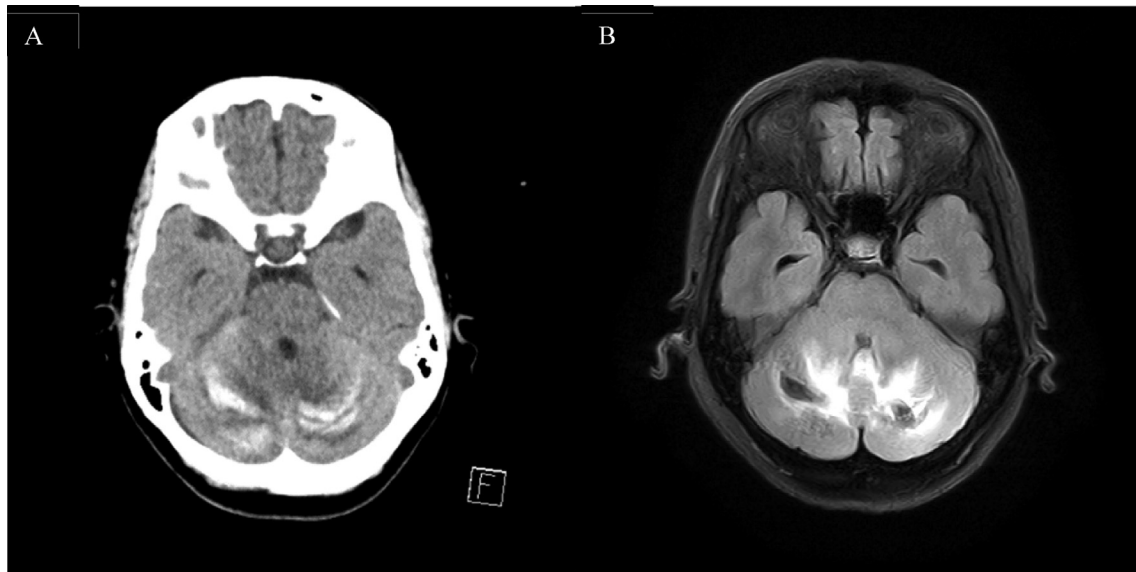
Brain Imaging Findings. Noncontrast-enhanced computed tomography on admission showed bilateral cerebellar hemorrhage (A). Fluid-attenuated inversion recovery magnetic resonance imaging obtained on day 7 showed persistent cerebral edema around the hematoma in the cerebellum (B).
